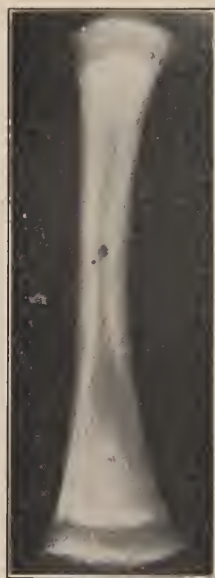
X-ray photograph of syphilitic bone.
